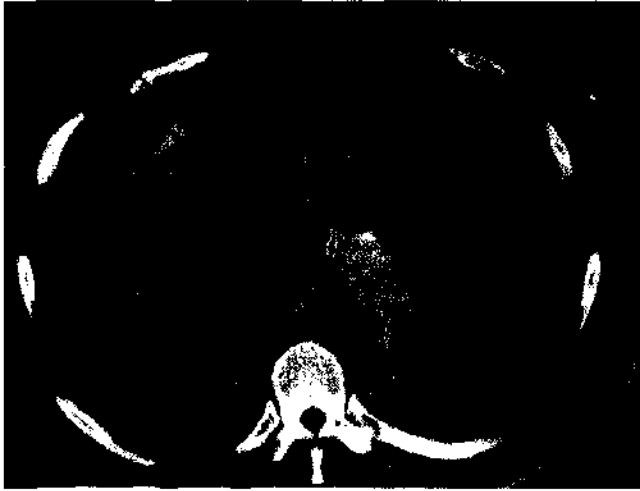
Axial abdominal CT image without contrast. Portal venous gas is present throughout the hepatic veins in this 54-year-old female with sepsis (arrowhead). Shortly, after obtaining the CT, the patient continued to decompensate, developed shock, and then expired.
